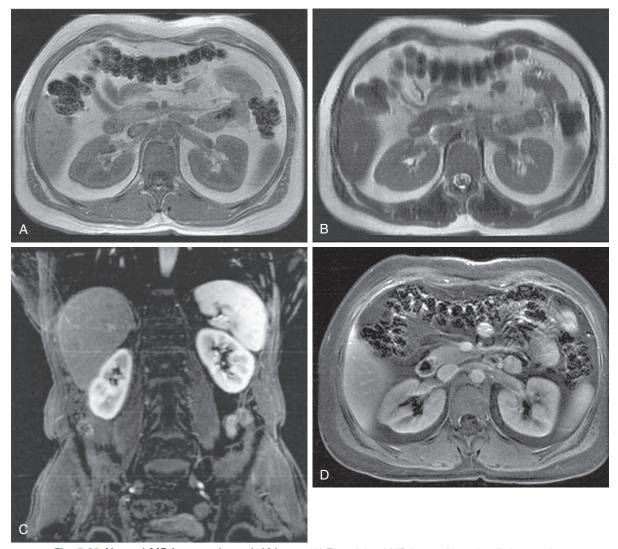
Normal MR images through kidneys. (A) T1-weighted MR image. Note the distinct corticomedullary differentiation. (B) Fast spin echo MR image. Urine in the collecting tubules causes the high signal within the renal pelvis on this sequence. (C) Coronal T1-weighted, fat-suppressed MR image after contrast administration. (D) Axial T1-weighted, fat-suppressed image after contrast administration.
